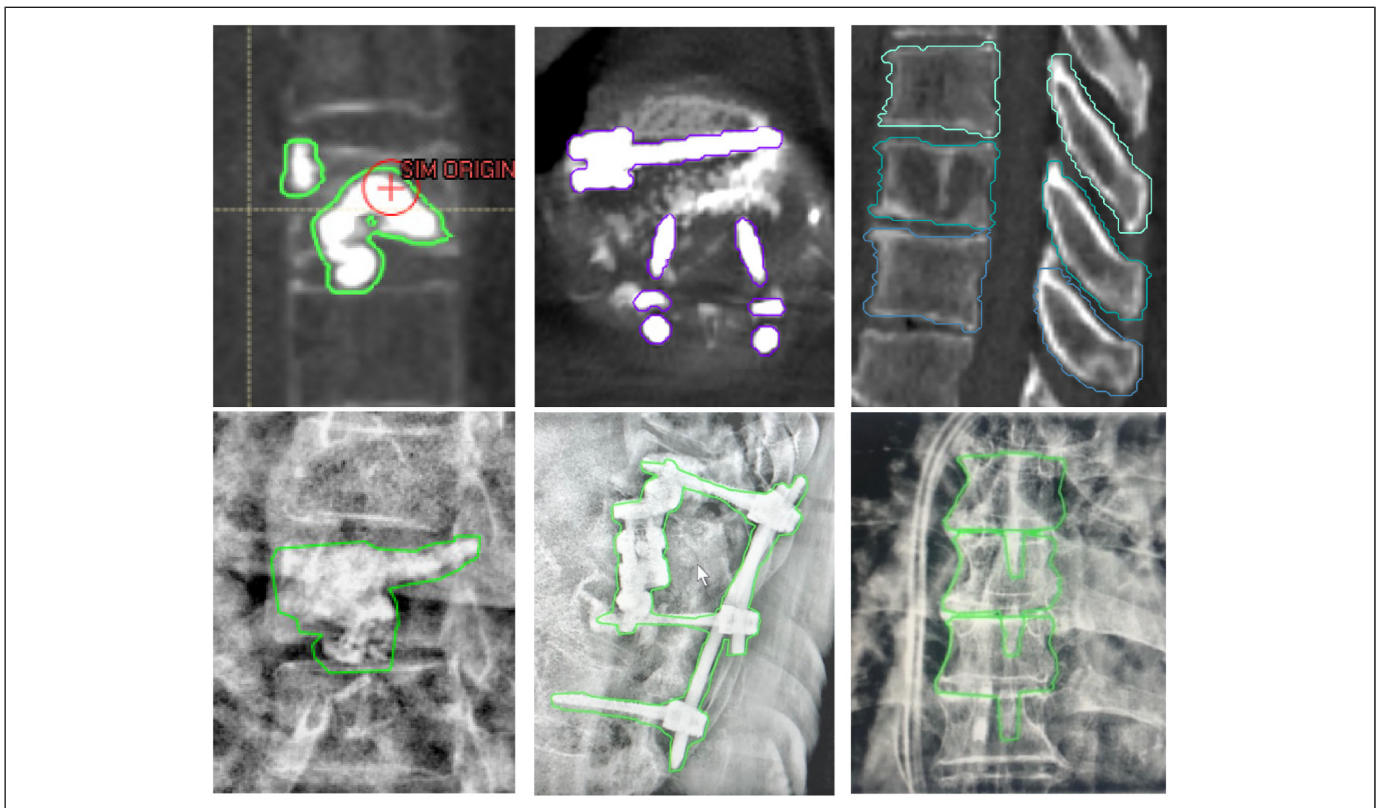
Example of the types of IGRT structures on planning CT (upper row) and projected onto triggered kV images (lower row). Bone cement (Left), orthopedic hardware implant (middle) and patient bony anatomy (vertebral body and spinous process, Right).
